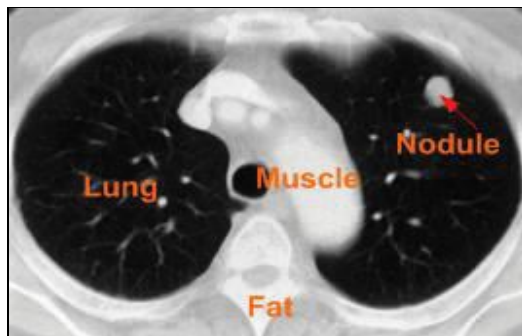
CT scans of lung nodule
